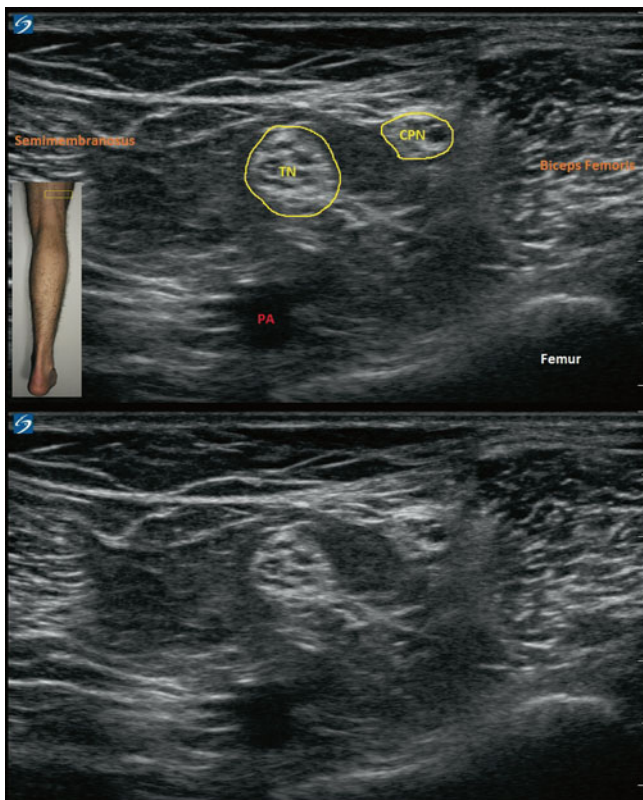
Ultrasound evaluation of the distal sciatic nerve. *PA* popliteal artery, *TN* tibial nerve, *CPN* common peroneal nerve (Image courtesy of Agnes Stogicza, MD)
